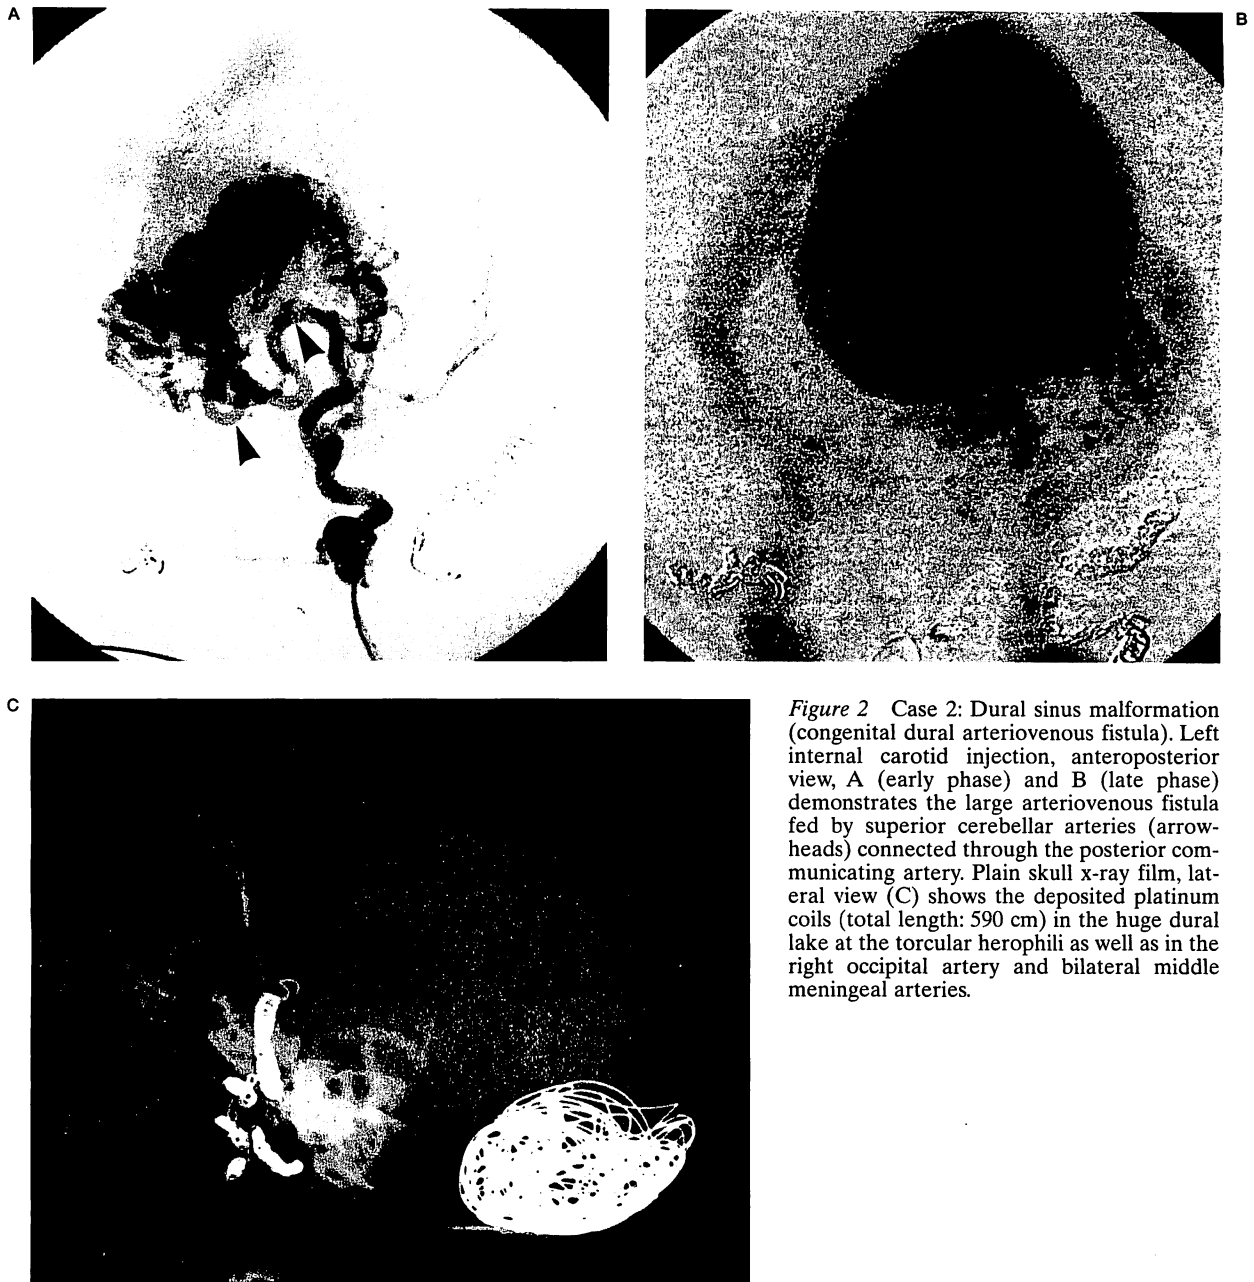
Case 2: Dural sinus malformation (congenital dural arteriovenous fistula). Left internal carotid injection, anteroposterior view, A (early phase) and B (late phase) demonstrates the large arteriovenous fistula fed by superior cerebellar arteries (arrowheads) connected through the posterior communicating artery. Plain skull x-ray film, lateral view (C) shows the deposited platinum coils (total length: 590 cm) in the huge dural lake at the torcular herophili as well as in the right occipital artery and bilateral middle meningeal arteries.
